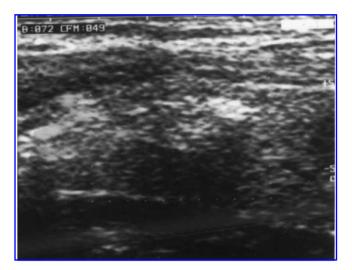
Ultrasound (US) B-Mode scan, a hyperechoic area with acoustic shadowing during laser thermal ablation (LTA) treatment.
